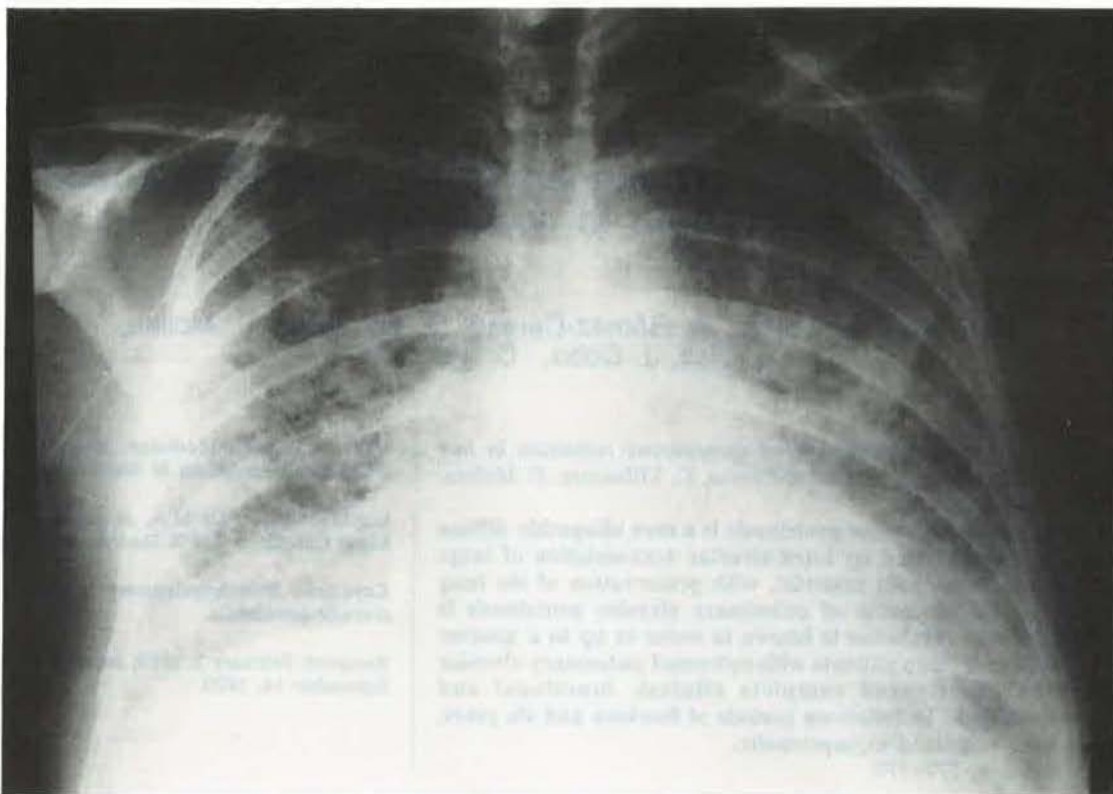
Chest X-ray (patient 1) at the time of diagnosis, showing diffuse bilateral alveolar infiltrates.
